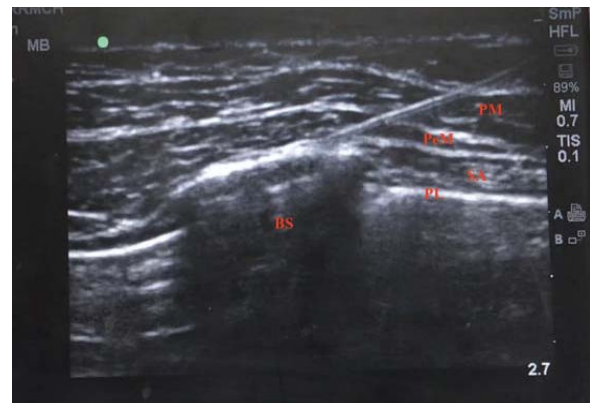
Ultrasonographic image showing needle pathway and sonoanatomy. PM = pectoralis major, PeM = pectoralis minor, SA = serratus anterior, PL = parietal pleura, BS = bony shadow.
